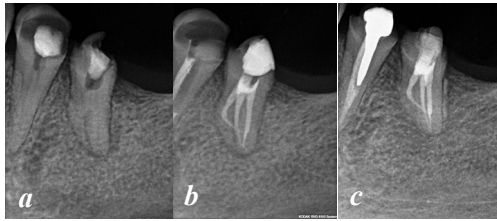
Fourth case, treatment of #35: (a) preoperative, (b) final and (c) 14 months control radiographs. Healing of the periapical lesion after the endodontic treatment of the tooth
